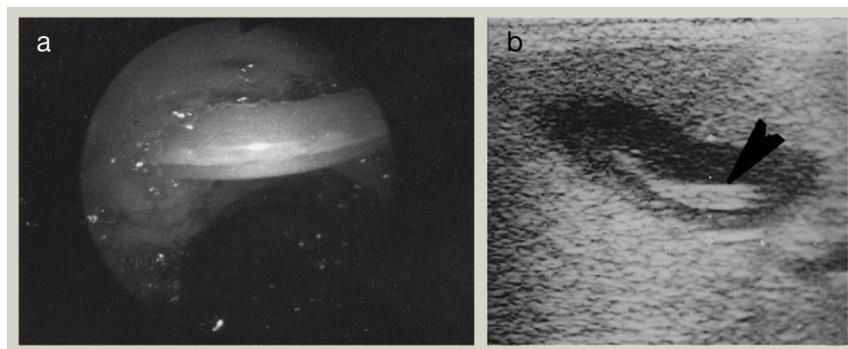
Spectrum of hepatobiliary ascariasis. (a) Endoscopic duodenoscopy shows the roundworm in the papilla of Vater. (b) Ultrasonography shows a long, linear echogenic filling defect (black arrow) in the gallbladder lumen. The defect is caused by the presence of the roundworm. Source: Courtesy of Professor Shoukat Ali Zargar, Sher-e-Kashmir Institute of Medical Sciences, Srinagar, India.
